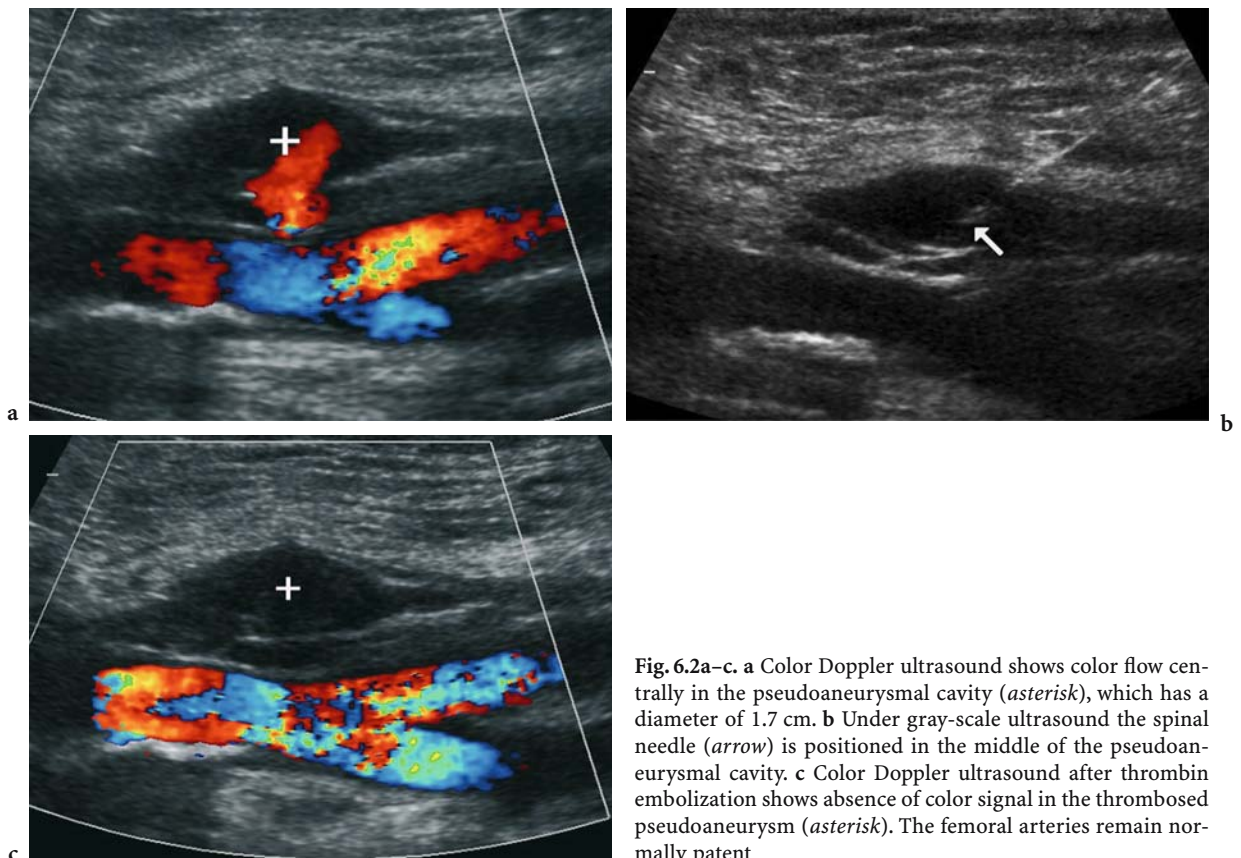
a Color Doppler ultrasound shows color flow centrally in the pseudoaneurysmal cavity (*asterisk*), which has a diameter of 1.7 cm. b Under gray-scale ultrasound the spinal needle (*arrow*) is positioned in the middle of the pseudoaneurysmal cavity. c Color Doppler ultrasound after thrombin embolization shows absence of color signal in the thrombosed pseudoaneurysm (*asterisk*). The femoral arteries remain normally patent
